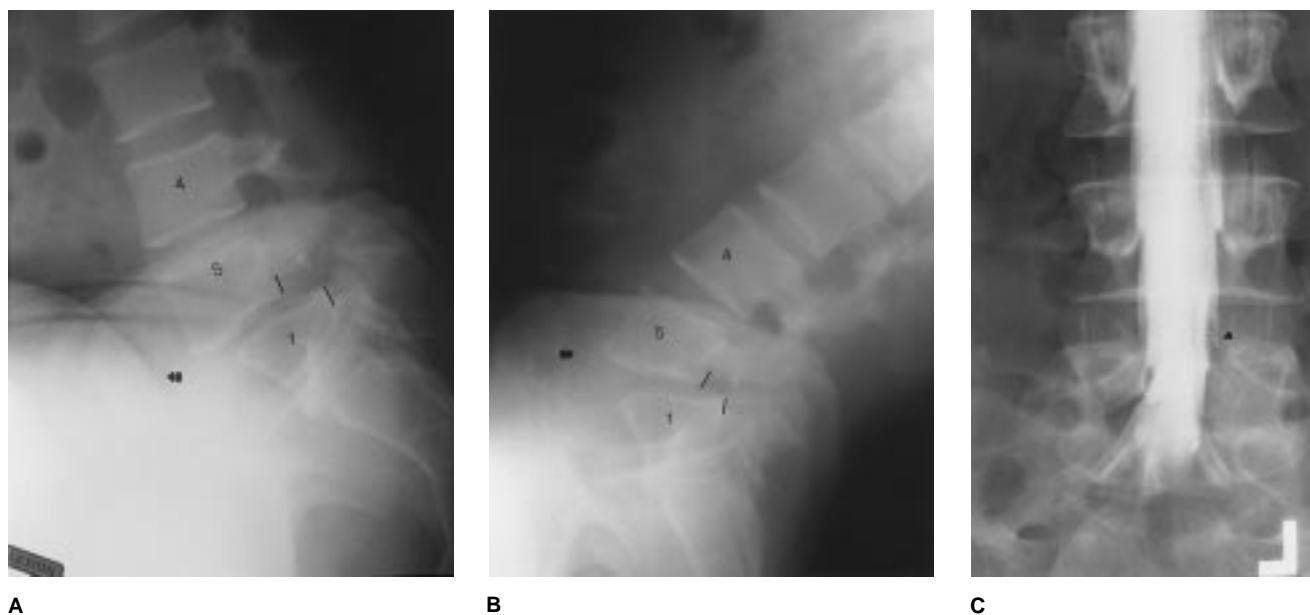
Images of a patient with L5-S1 spondylolisthesis. Lateral lumbar radiographs depict isthmic spondylolisthesis with dynamic translation of L5 on S1 with flexion (A) and extension (B) (arrows indicate direction of movement; bars indicate limits of translation on flexion/extension). C, AP lumbar myelogram depicts the cutoff of the left L5 root (arrowhead), which correlates with the patient's symptoms of left leg radiculopathy.
